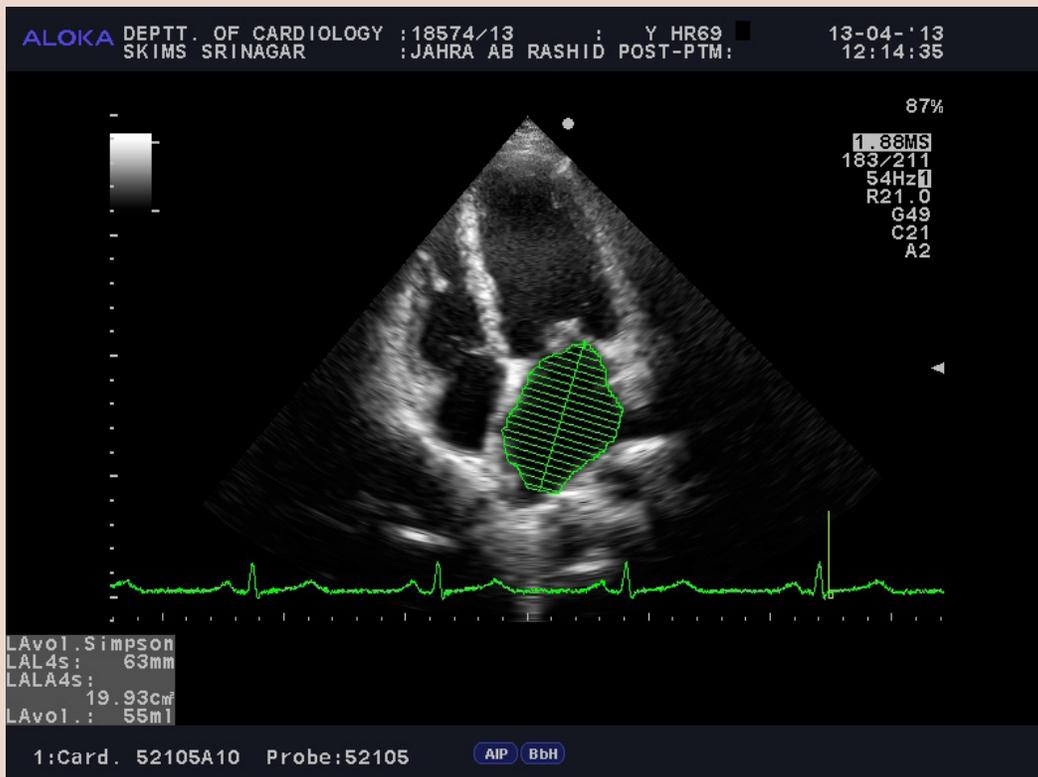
Measurement of minimal LA volume (V_{min}) by modified Simpson's method in apical 4-chamber view.
